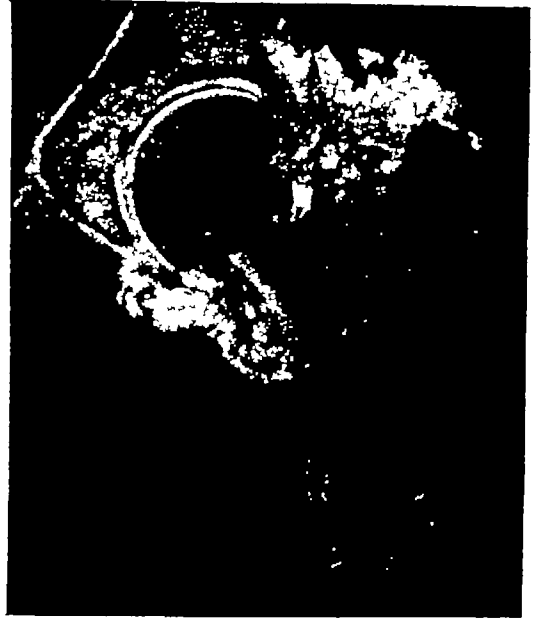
b—Check roentgenogram re figure 1667, 45 months after injury The sequestrum has further diminished in size Normal density and almost normal structure of the head Patient walks well
